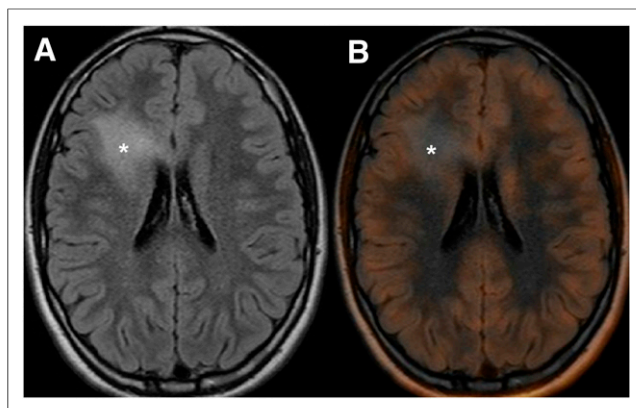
(A and B) Diffuse astrocytoma (WHO grade II) (case 4). Diffusely infiltrating lesion (*, FLAIR image, A) demonstrating absence of tracer uptake on ^{18}F -DOPA PET/MR imaging fusion (*, B).
